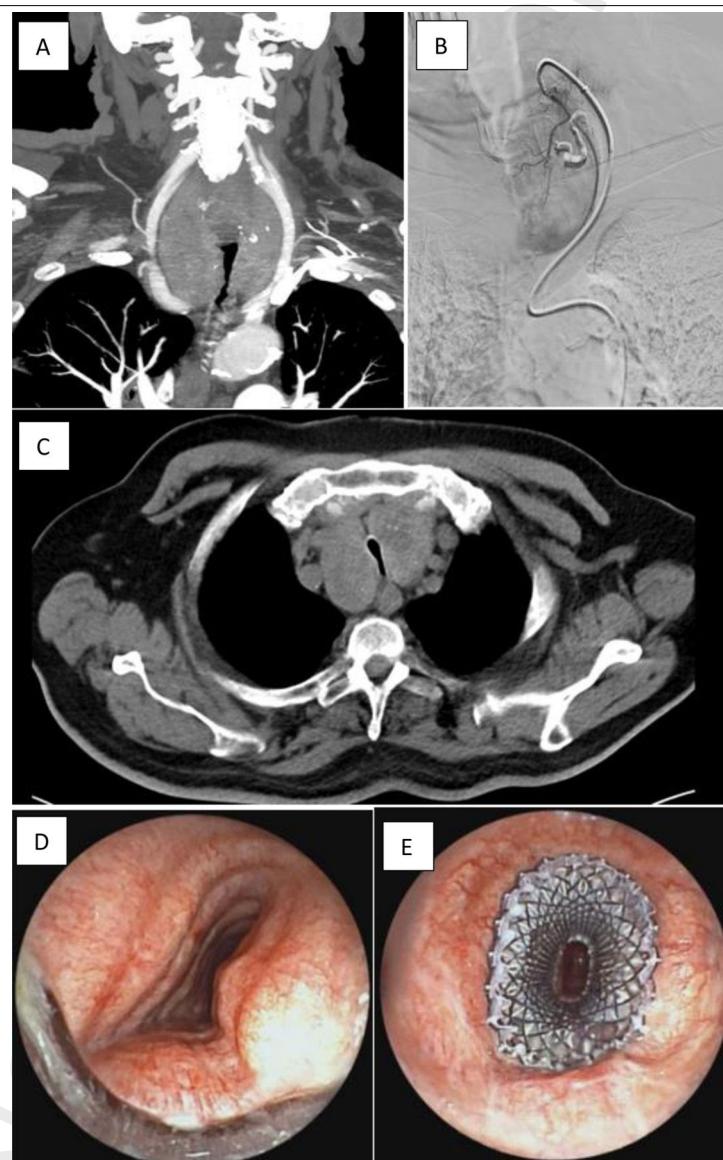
(A and C) Endothoracic goiter with 80% proximal tracheal stenosis CT-scan. (B) Selective embolization of thyroid arteries. (D and E) Rigid bronchoscopy, metallic stent placement.
